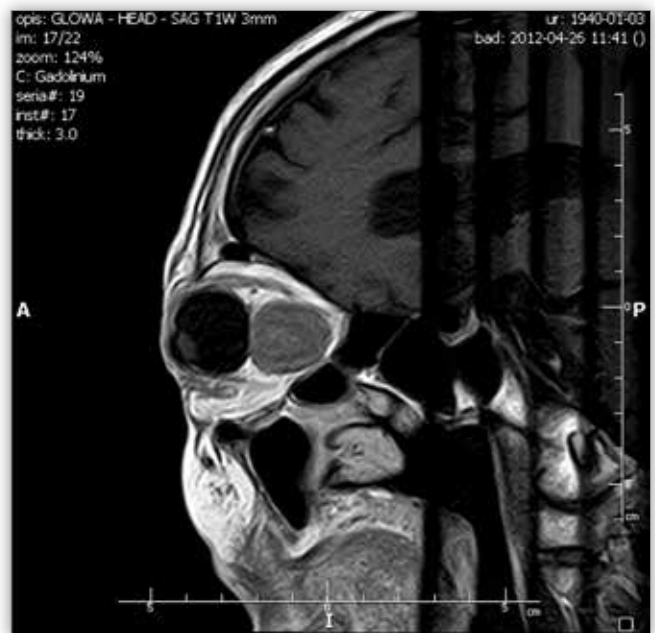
Large tumor-like lesion behind the left eye visualized on T1-weighted CT scan in sagittal cross-section.
